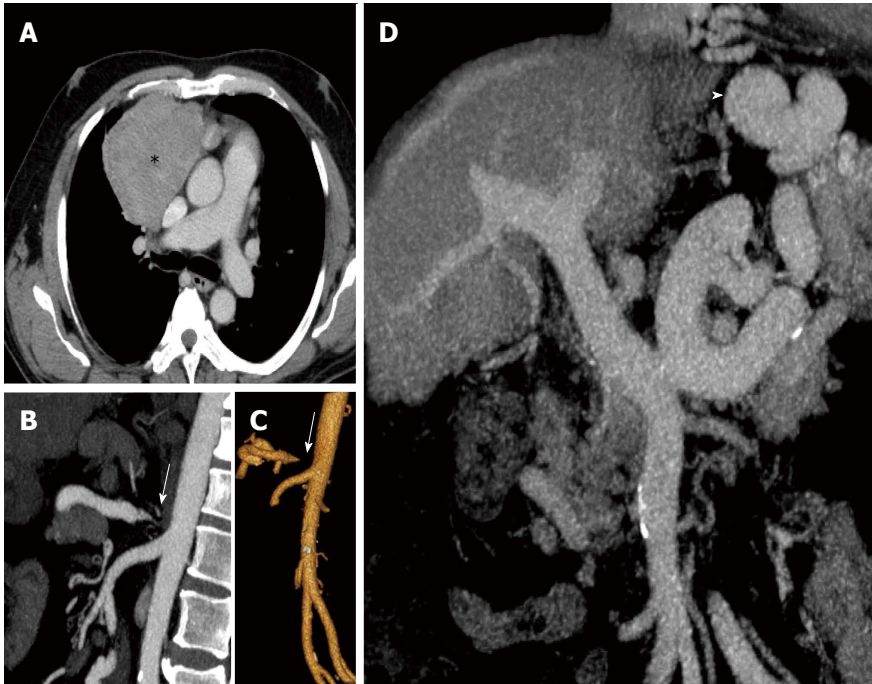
Axial, coronal and sagittal reconstructions of enhanced-computed tomography scan of the patient. A: Shows the anterior mediastinal mass (Asterisk) compressing and displacing the adjacent structures (after biopsy, the patient was diagnosed with thymoma). To reverse the thrombocytopenia to initiate chemotherapy treatment, the first option was splenic artery embolization, but this was contraindicated due to severe stenosis of the celiac trunk [arrows in (B) and (C)]; D: Cirrhotic liver, and the large portal trunk caliber, all characteristics of severe portal hypertension secondary to schistosomiasis. Also of note, the large sized collateral circulation (arrowhead in D) common to this profile.
